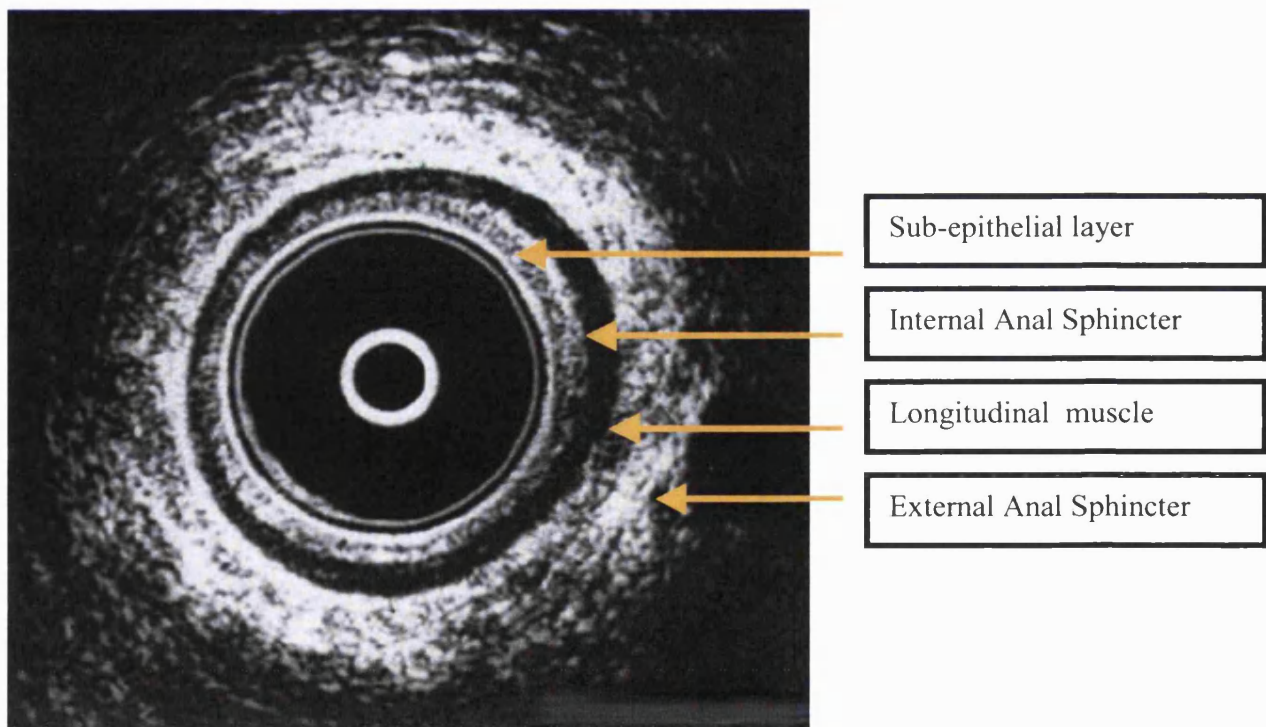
Endoanal ultrasound image
